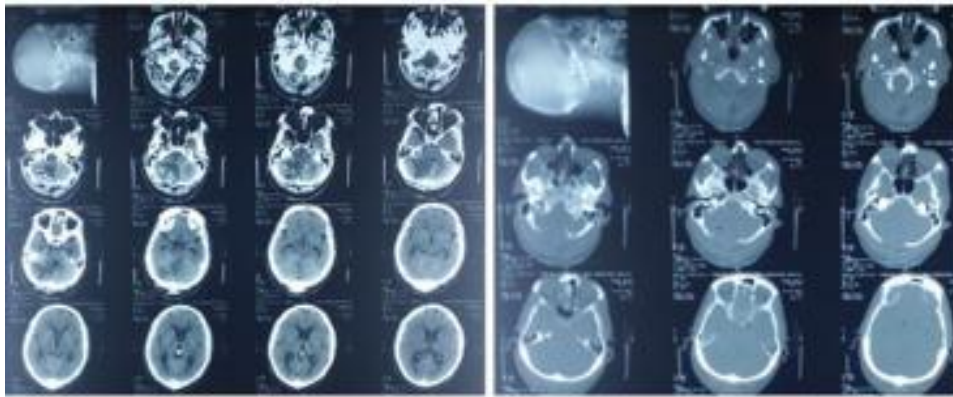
B: Postoperative CT scan of Case 1.
